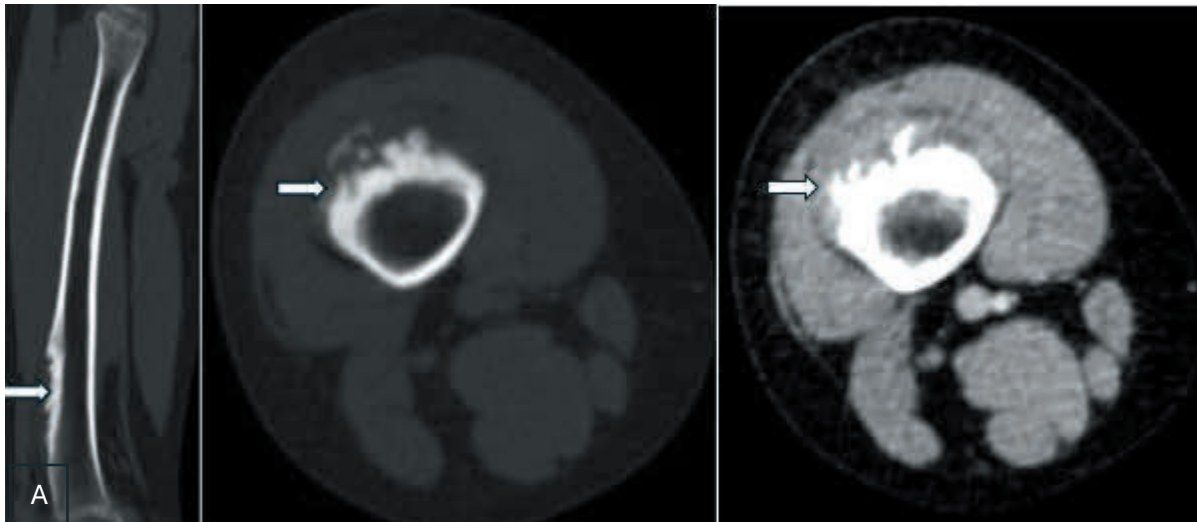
CT images of the right femur revealed an ill-defined subperiosteal osteolytic lesion with heterogeneous attenuation along the cortical surface of the distal third of the femoral shaft. The lesion was associated with subjacent cortical thickening and an irregular periosteal reaction. A slight increase in attenuation was observed in the anterior portion of the underlying medullary cavity at the level of the lesion. No evidence of mineralized matrix formation was presented, and there was no extension into the adjacent soft tissues.
